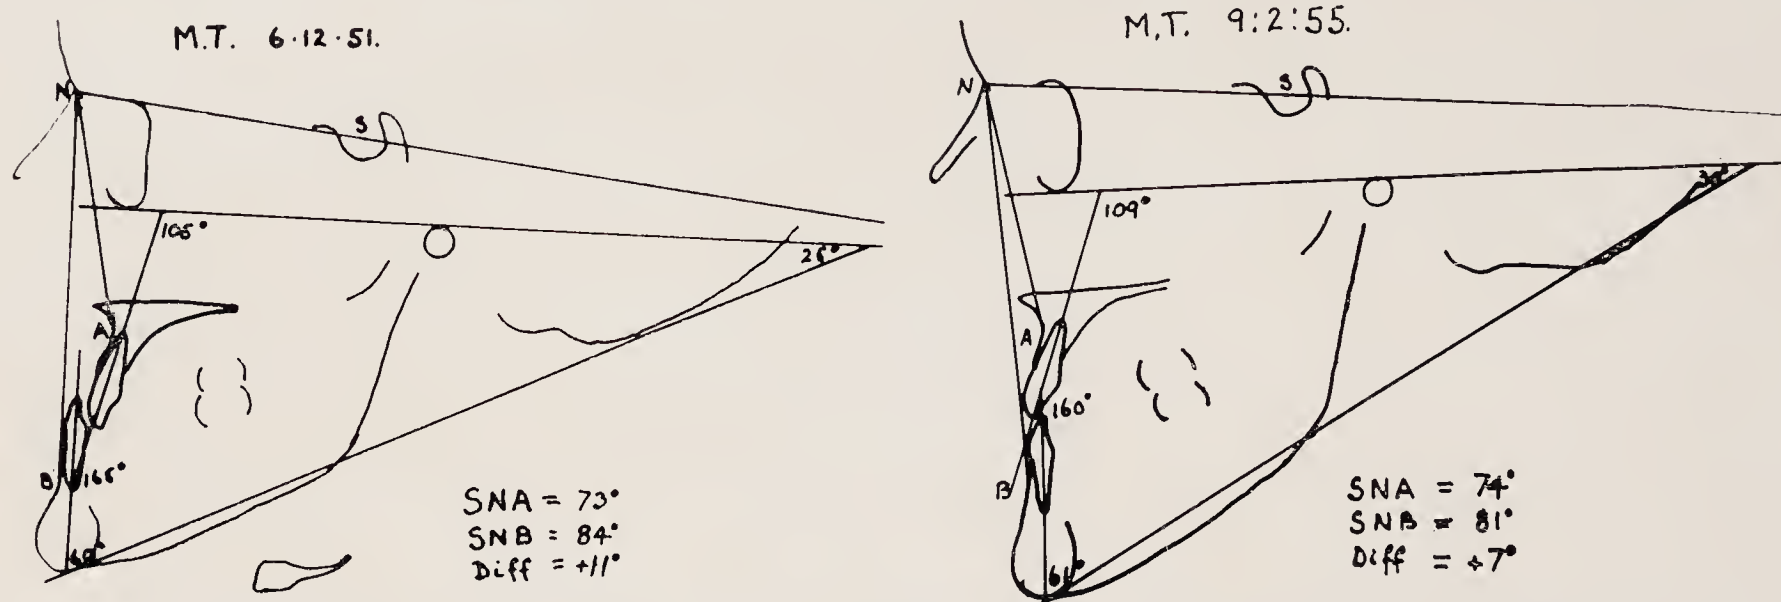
Tracings of lateral skull X-rays of patient with a Class III (Angle) malocclusion on an intermediate type of skeletal pattern before and after treatment. There was a slight over-closure factor. It was only necessary to tip the upper incisors labially a few degrees to overcome the mesial displacement of the mandible and the improved incisor relationship is not traumatic. $\frac{4}{6}$ were extracted.
